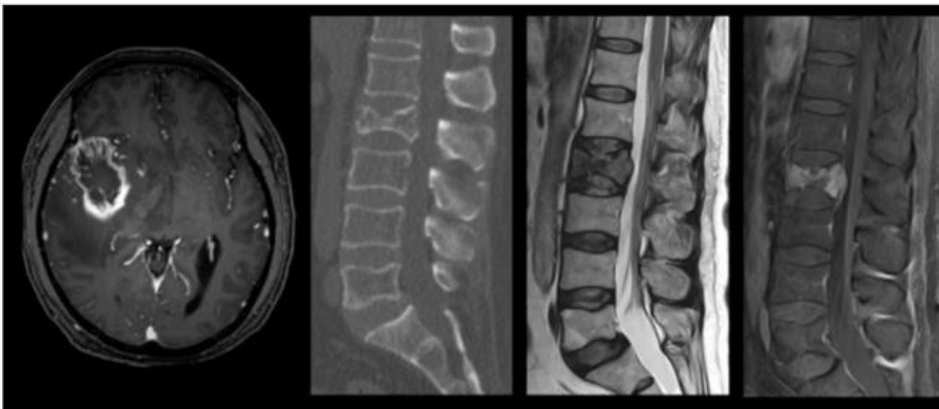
Baseline imaging of the brain demonstrated a rim-enhancing, centrally necrotic infiltrating mass in the right temporal lobe with extensive surrounding vasogenic edema on post-contrast axial T1-weighted image. Sagittal CT of the abdomen and pelvis demonstrated a pathologic fracture of L2 with a mixed lytic and sclerotic lesion and mild bulging of the posterior cortex. T2-weighted image showed heterogeneous hyperintensity and post-contrast axial T1-weighted image showed heterogeneous enhancement and pathologic compression fracture of the L2 vertebral body.
